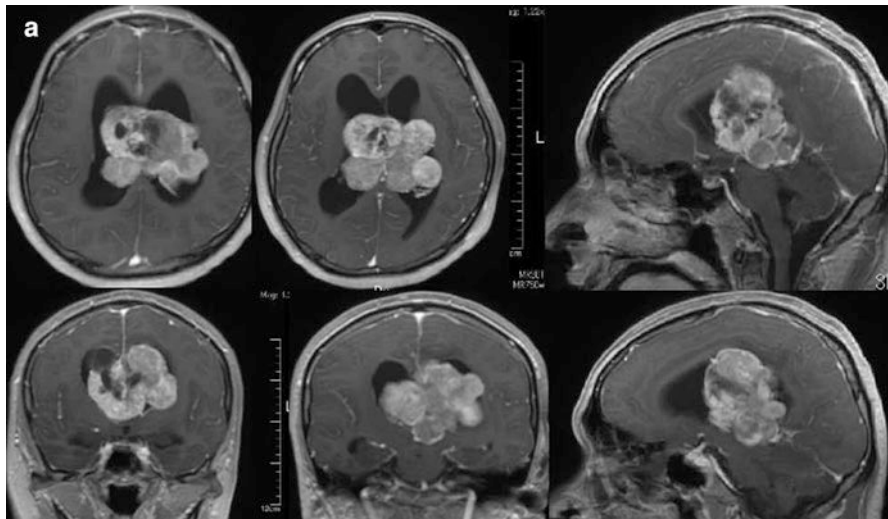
A 36-year-old man with large bilateral intraventricular meningioma with intracranial hypertension. Panel a depicts the preoperative MR images, and Panel b the postoperative MRI images after multiple surgeries. The small residual tumor has been irradiated by cyberknife, but further small growth of the tumor obliged us to operate again, and finally, total removal has been accomplished. The patient is complaining of right spastic hemiparesis, which is improved by Botox injection
